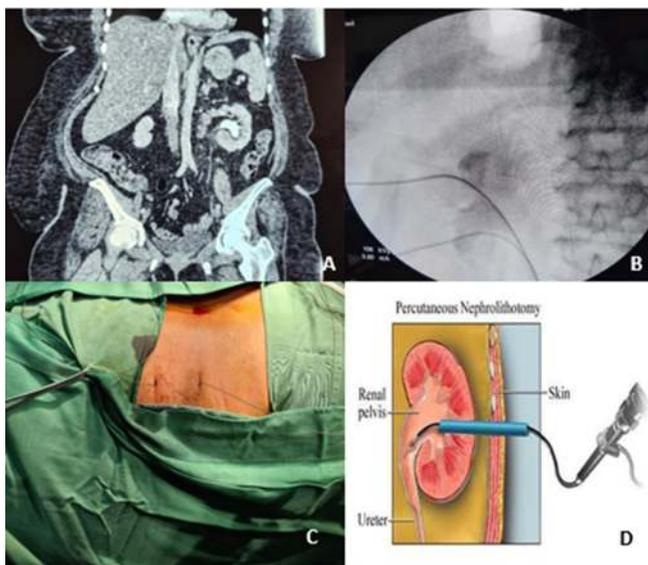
A-morbidly obese patient with a complete left staghorn stone on CT scan. B & C – Two guidewires are passed into the kidney under fluoroscopy. D – These tracts are subsequently dilated and instruments are then passed into the kidney.
